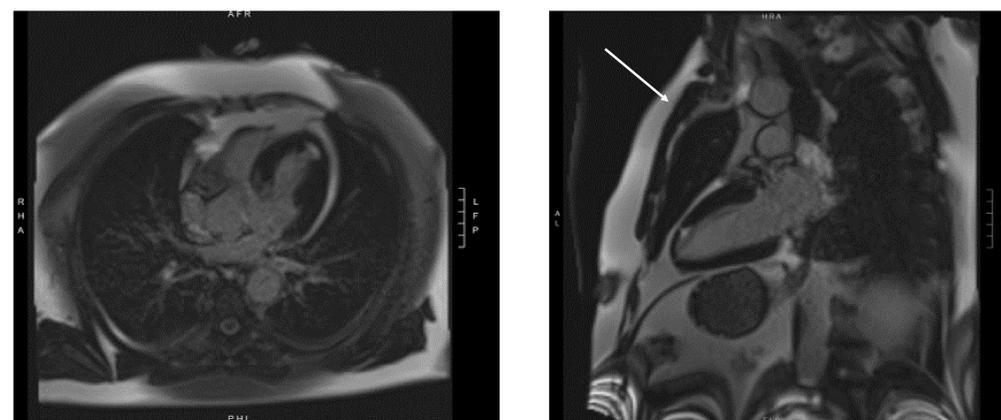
Cardiac MRI demonstrating LGE at the apex (white arrow).
